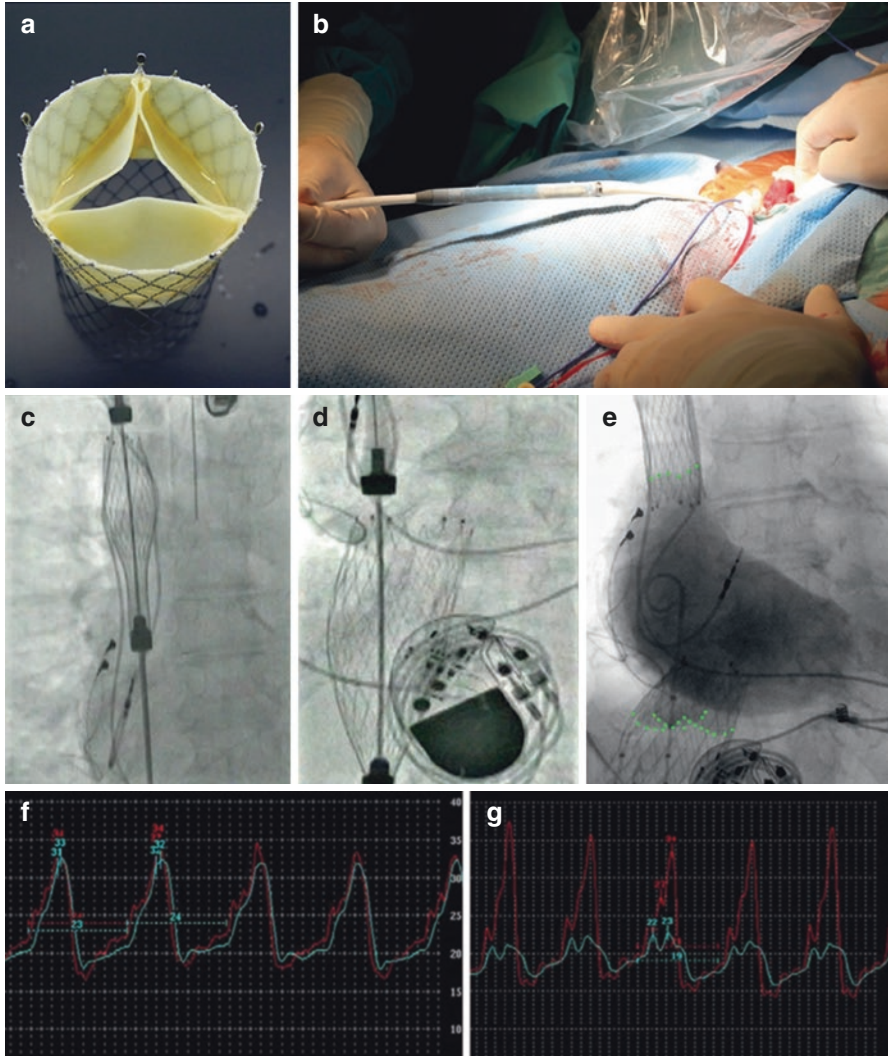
CAVI with the Tric valve device. (a and b) The pericardial valve mounted on a self-expandable nitinol stent is loaded into a 27-F catheter for implantation. (c–e) After transfemoral access and under *fluoroscopic* and *echocardiographic* guidance, the SVC and IVC valves are sequentially deployed. Transjugular pacer leads are jailed by the SVC stent. Reprinted with permission from Lauten et al. [29]. (f and g) Pressure measurement confirms a reduction of the ventricular wave and mean pressure in IVC pressure from 32 mm Hg to 23 mm Hg and 24 mm Hg to 19 mm Hg, respectively. Blue tracing $\frac{1}{4}$ inferior vena cava; red tracing $\frac{1}{4}$ right atrium. CAVI $\frac{1}{4}$ caval valve implantation; IVC $\frac{1}{4}$ inferior vena cava; SVC $\frac{1}{4}$ superior vena cava
